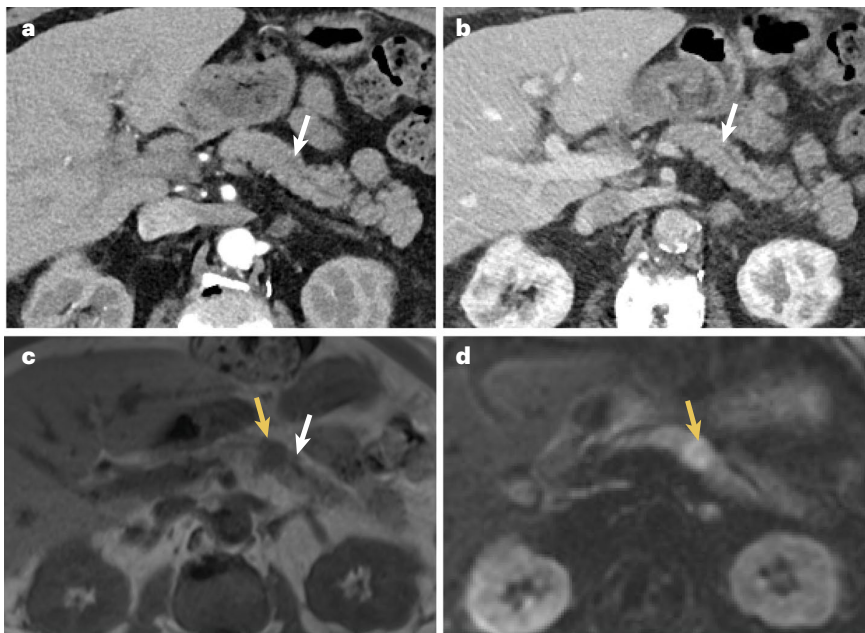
CT and MRI imaging for pancreatic cancer staging. CT scans during arterial (panel a) and portal venous (panel b) phase show dilation of the pancreatic main duct in the pancreatic tail with duct interruption (white arrows), but no lesion is visible. On MRI images (on both the native T1-weighted image (panel c) and the diffusion-weighted image ($b = 800$) (panel d)) the causing tumour can be clearly delineated (yellow arrows; hypointense on the T1-weighted image, hyperintense on the diffusion-weighted image).
